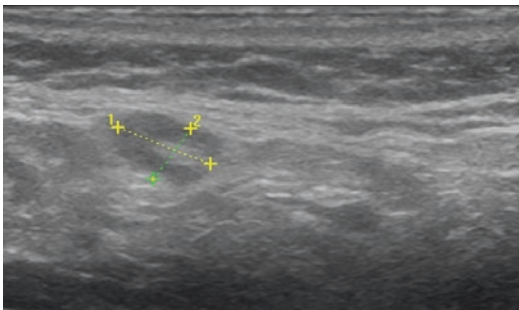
Ultrasound examination of parotid gland in a patient with Sjögren's syndrome often reveals a shrunken gland with hyperechoic scar and scattered lymph nodes (marked) (Image courtesy of M. Boyd Gillespie, MD)
